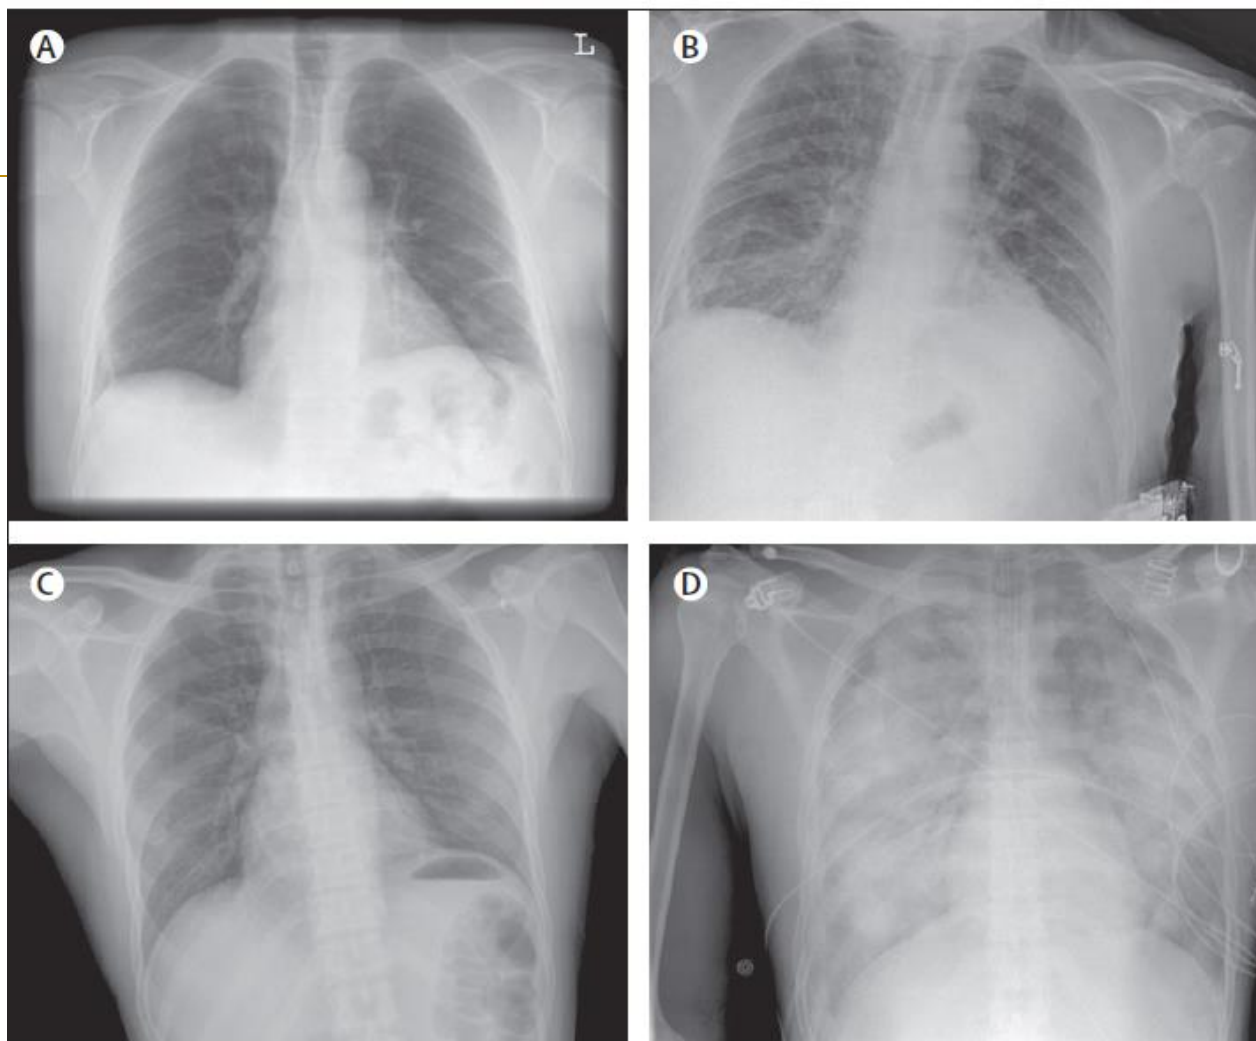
Chest radiographs of patients presenting with transfusion-related acute lung injury (TRALI) Chest radiographs of two patients before (A, C) and after (B, D) onset of TRALI. Radiographs A and C show normal pulmonary vasculature with no signs of pulmonary oedema; B and D show infiltrative changes suggestive of pulmonary oedema. D shows the classic severe bilateral infiltrative changes that present with TRALI; however, frequently such changes are less apparent with chest x-rays, as shown in B.
